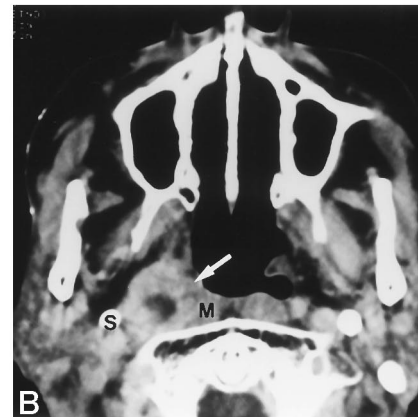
92-year-old man with squamous cell carcinoma of the upper gingiva (T2N0M0). A, Contrast-enhanced axial CT scan shows recurrent tumor of the upper neck region on the right side (arrow).
